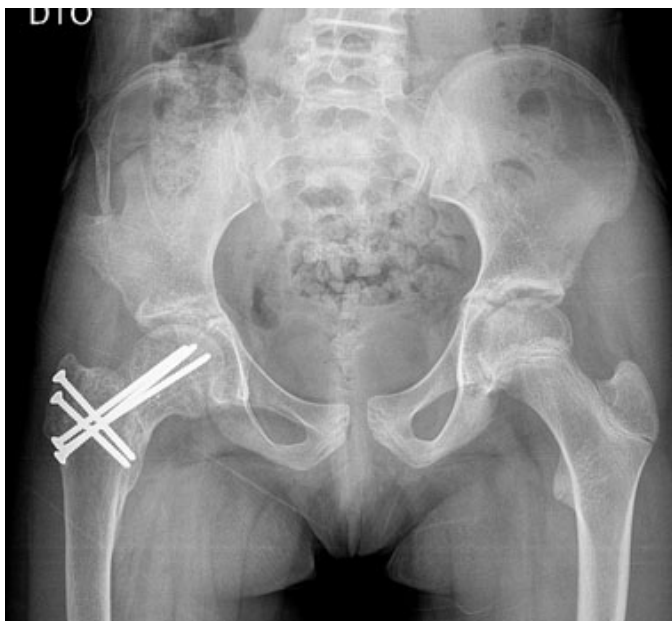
Anteroposterior pelvis X-ray nine months after the second surgery showing fracture consolidation.
